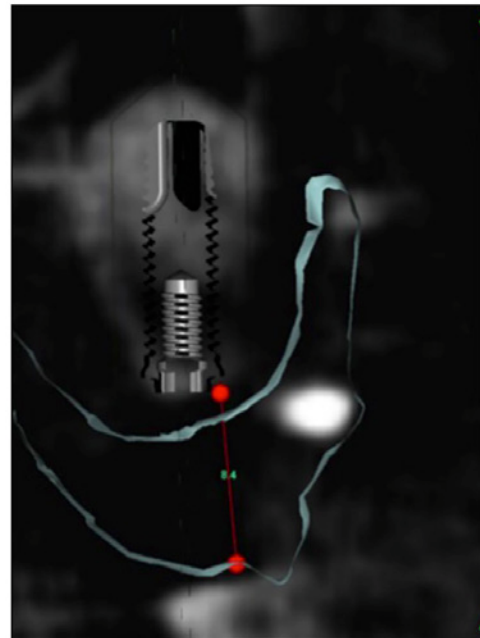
Vertical restorative space calculated on the CBCT cross-sectional image.
